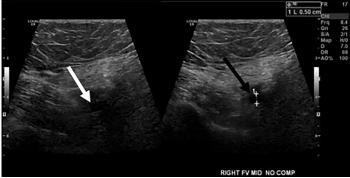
Ultrasound image of the femoral vein on the right side without compression (white arrow) and with compression (black arrow). The femoral vein was uncompressible, consistent with a venous thrombosis.
